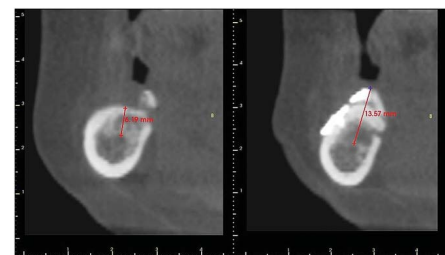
Measurement taken during the cone beam computed tomography immediately before the surgical procedure and in the 4-month postoperative period. A vertical gain of 7.38 mm was recorded in the case involving the posterior region of the mandible.
